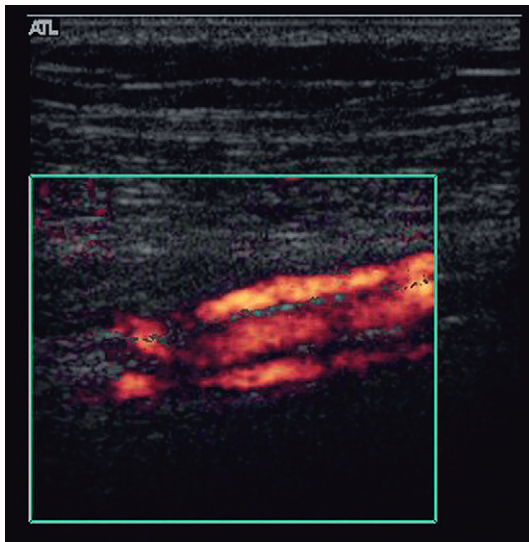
Power Doppler showing paired deep calf veins running with the artery.
